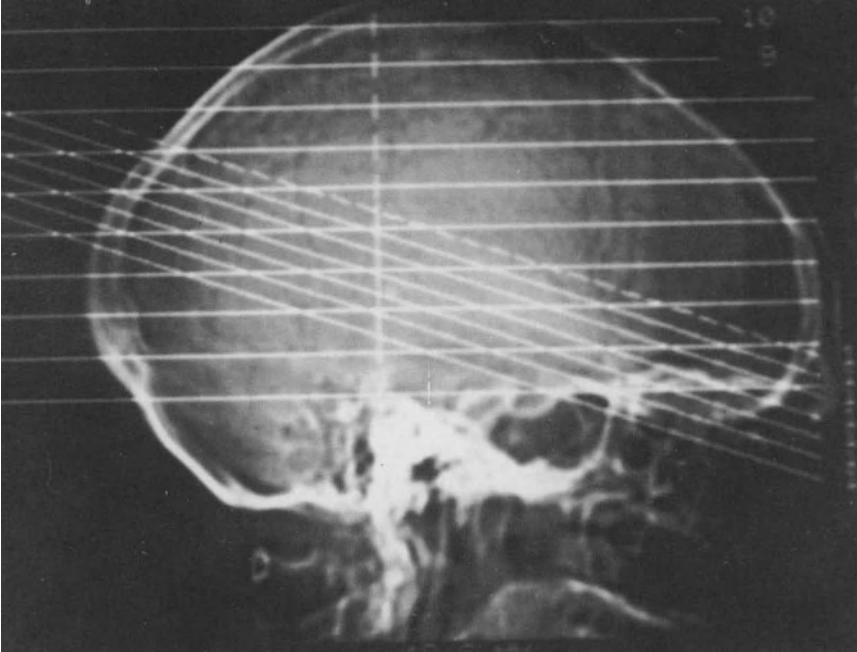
Lateral CT scout depicting the conventional canthomeatal plane (*scans 1–10*) and the negative angulation (*scans 11–17*)
